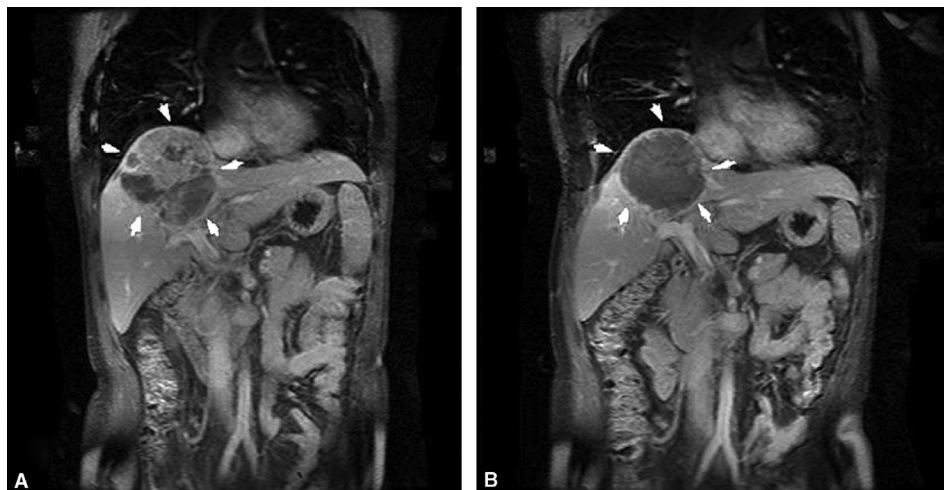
Post-contrast coronal MRI of a hepatic tumor treated by ultrasound guided HIFU [1]. A. Right hepatic lobe tumor showing heterogenous contrast enhancement before treatment. B. After HIFU therapy, no significant enhancement is seen denoting adequate tumor ablation.
